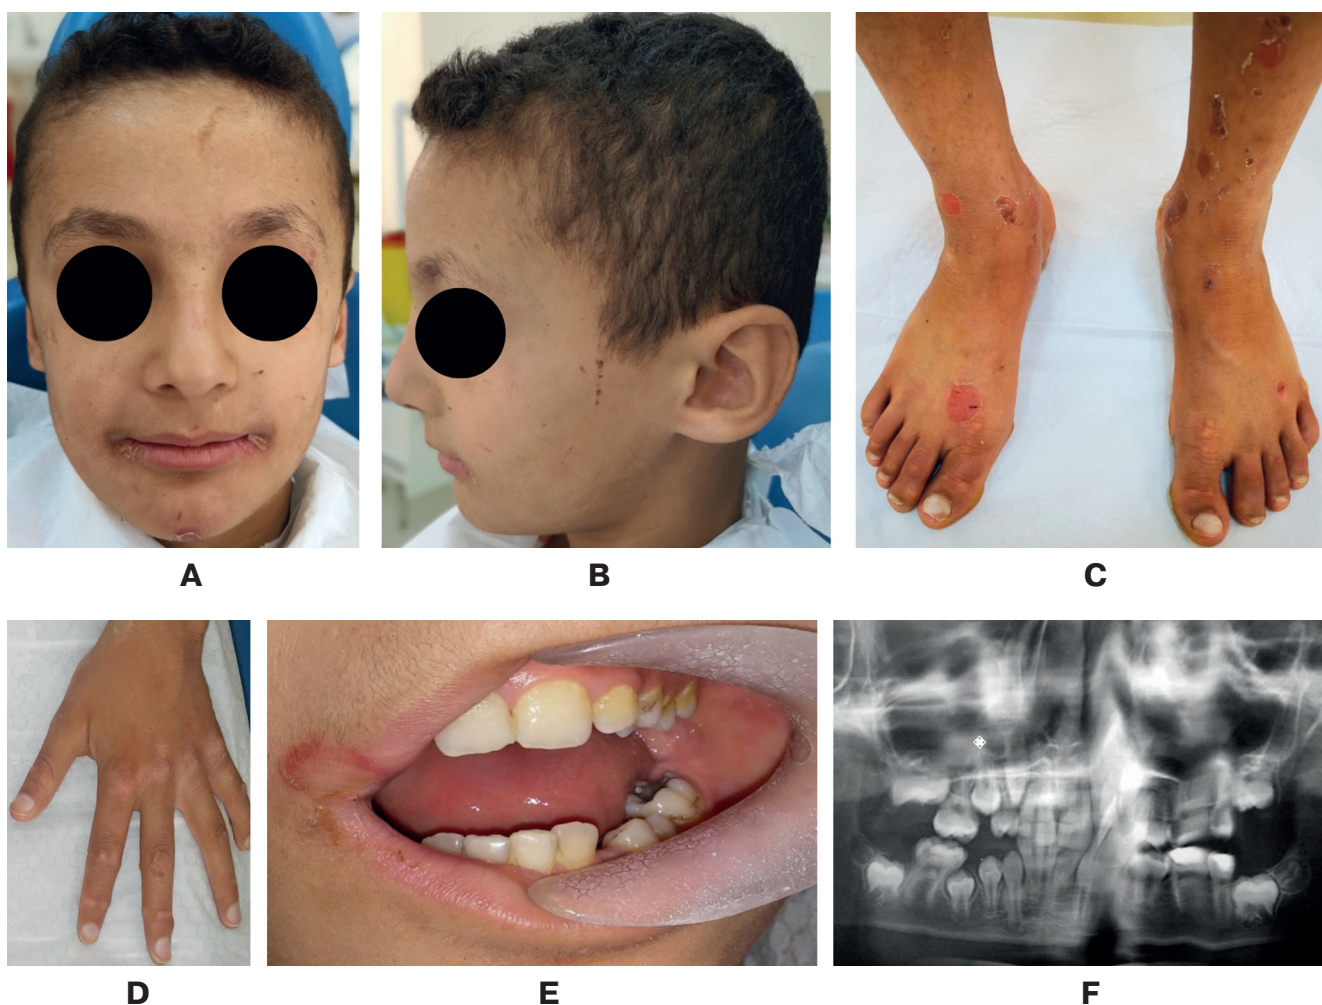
Case 4: *A* – frontal craniofacial image, showing perioral erosions and scarring; *B* – lateral craniofacial image, displaying additional scarring along the cheek and jawline; *C* – foot image, highlighting multiple erosions and hyperkeratotic lesions; *D* – hand image, demonstrating scarring and dystrophic changes; *E* – intraoral image, showing dental plaque accumulation and Nasmyth's membrane, especially on the posterior teeth; *F* – panoramic radiograph, with suboptimal image quality
